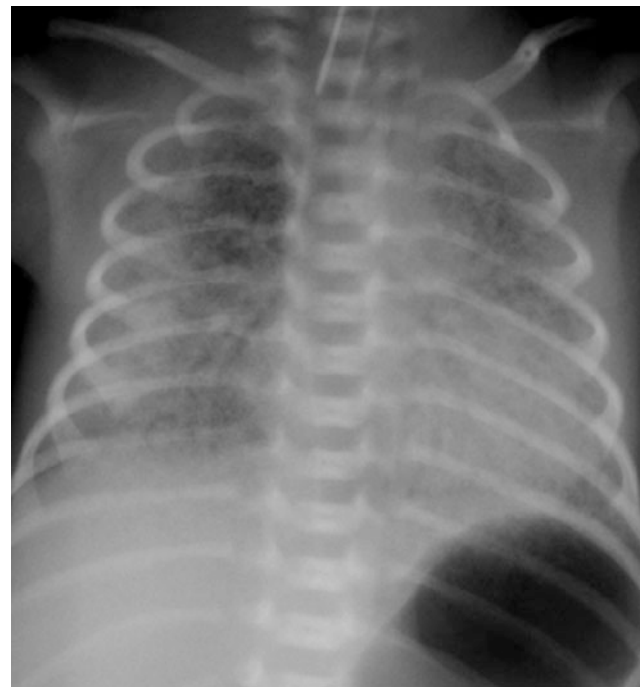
Effect of surfactant administration. a Initial radiograph of a newborn with respiratory distress syndrome (RDS) taken following intubation. Fine granular opacities are present bilaterally. b Radiograph
